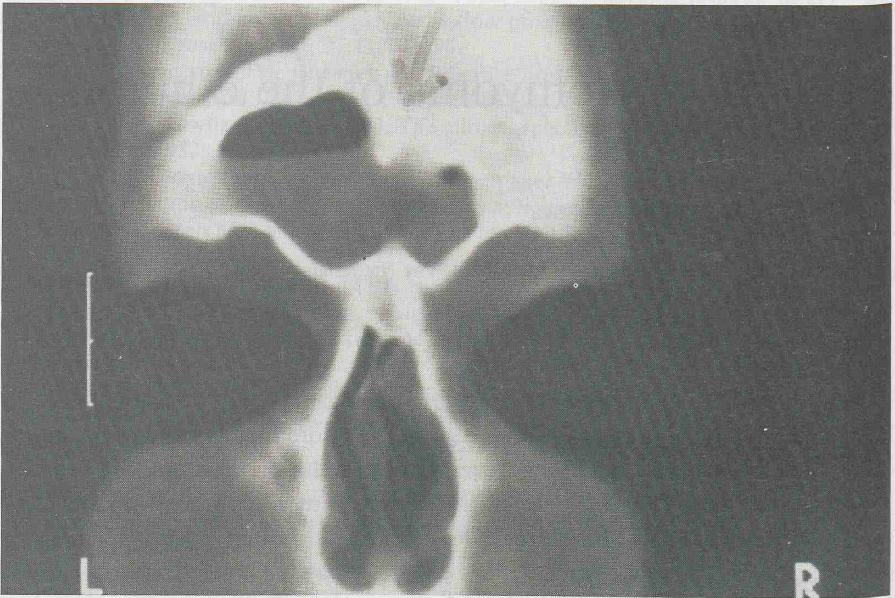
The left sinus frontal showing a fluid level on the coronal CT-scan. Thus pointing out a complete blockage of the nasofrontal duct. At the right side a chronic sinusitis can be suspected.
